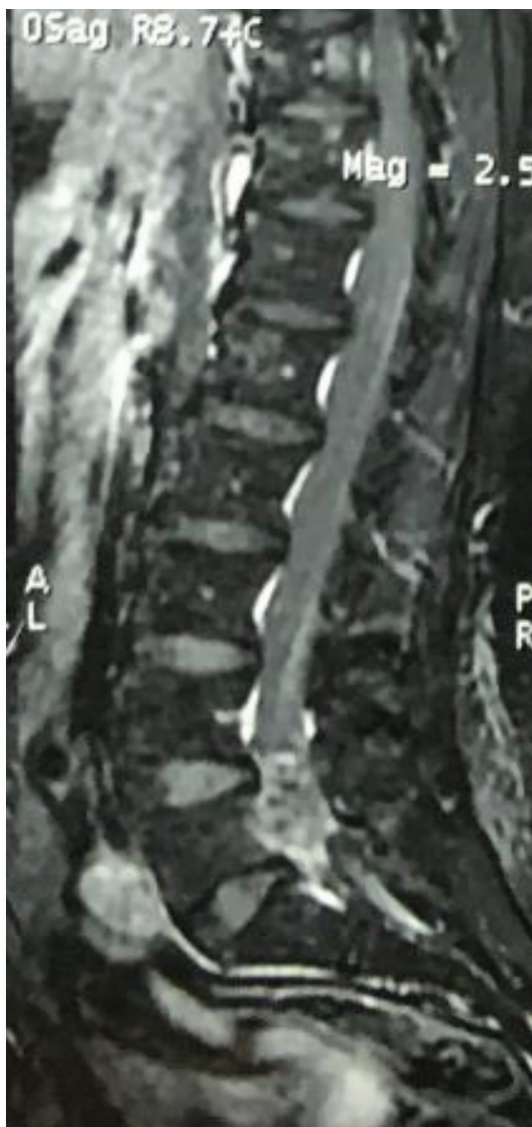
Sagittal T1 MRI with GD enhancement. The tumor was enhanced diffusely. GD, gadolinium; MRI, magnetic resonance imaging.
